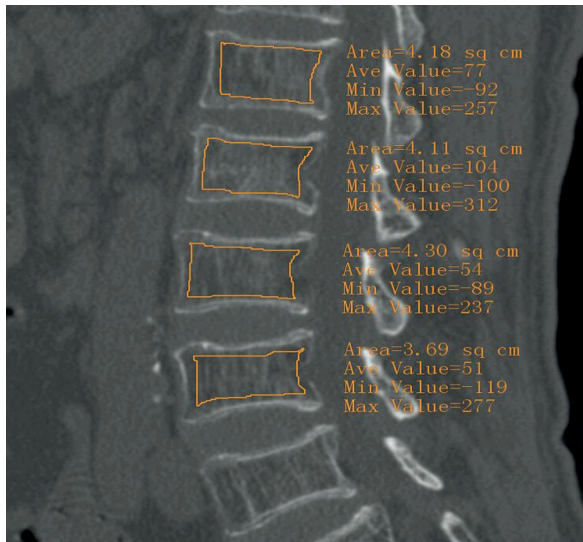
ROI area and mean HU value of trabecular bone regions of TV and adjacent vertebral body calculated based on the sagittal CT image.
